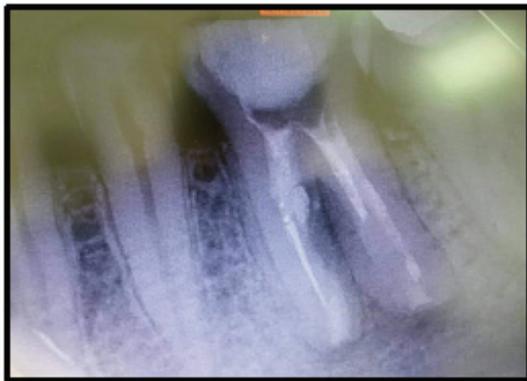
periapical radiograph showed no evidence of resorption.
